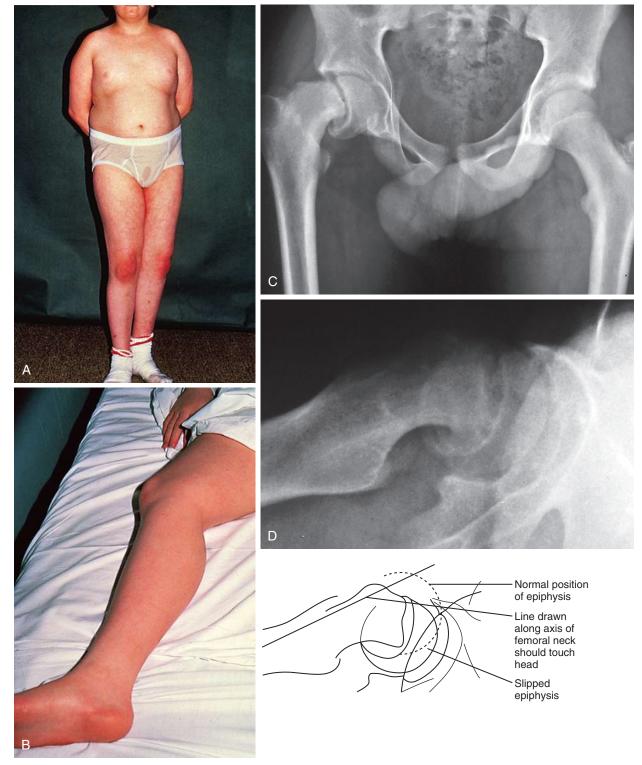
Slipped capital femoral epiphysis. A, This obese boy presented with a painful limp during early puberty. Note his reluctance to bear weight on the involved right leg. B, When he lies supine, the affected leg is positioned in external rotation because this minimizes discomfort. Attempts at motion produce pain in the acutely slipped epiphysis. C, In the anteroposterior radiograph the right femoral head is displaced medially in relation to the femoral neck as a result of epiphyseal separation. D, In the lateral view the femoral head is seen to be displaced posteriorly in relation to the femoral neck. A line drawn along the axis of the femoral neck should normally touch the head.
